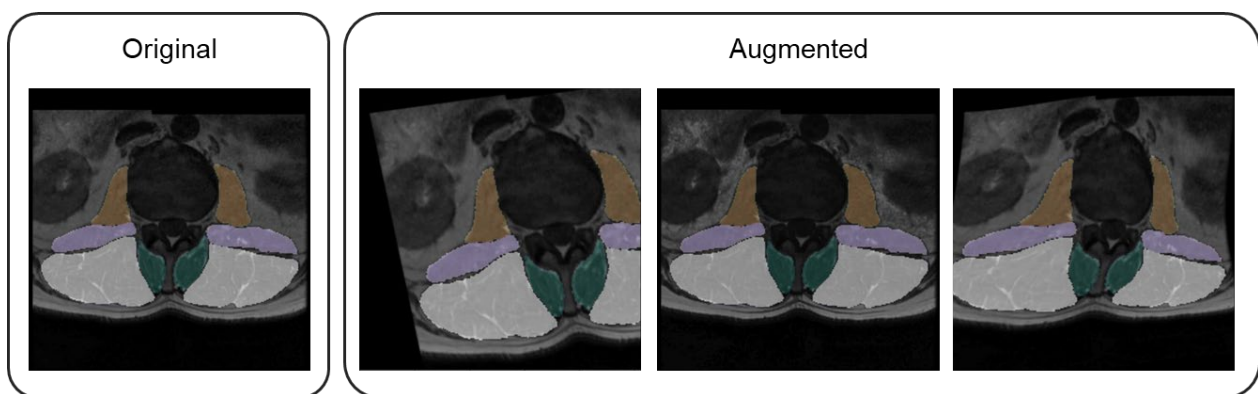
Example of data augmentation in lumbar spine MRI. The image and segmentation labels are manipulated in the conjunction to introduce plausible variance in the training set.
